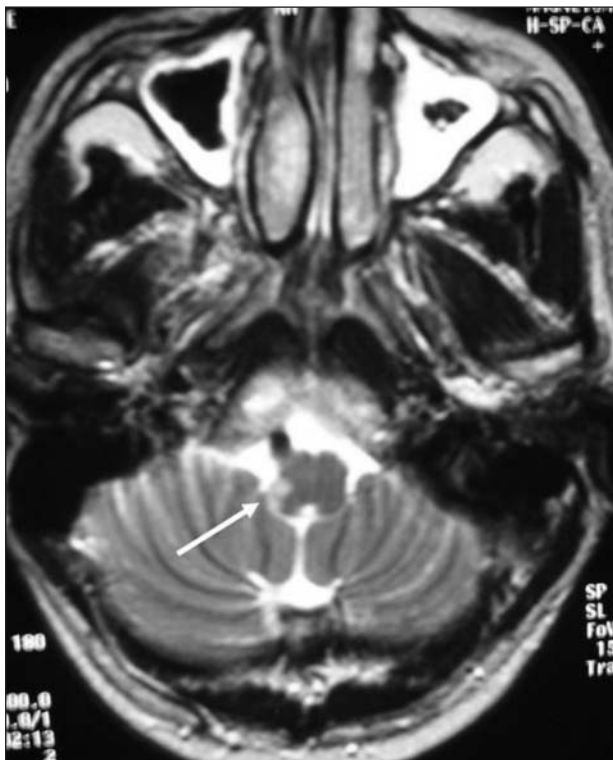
MRI showing a right dorsolateral medullar infarction (arrow).
